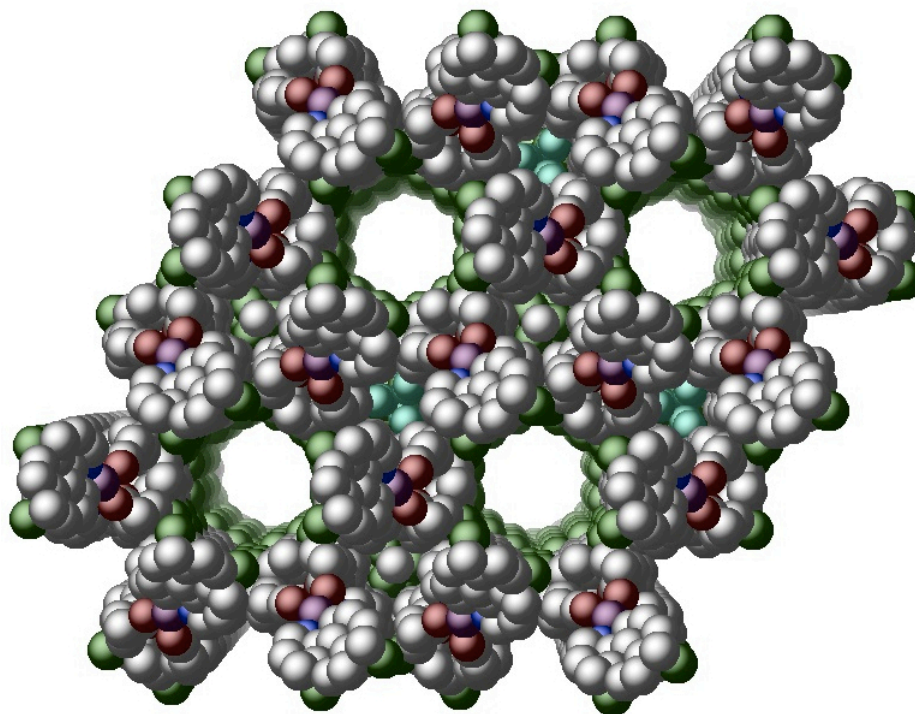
Space-filling projection of the X-ray structure of 1.11, viewed down the Pd–Pd axis, showing empty pores lined by the chloride substituents on the cyclometallated ligands.
